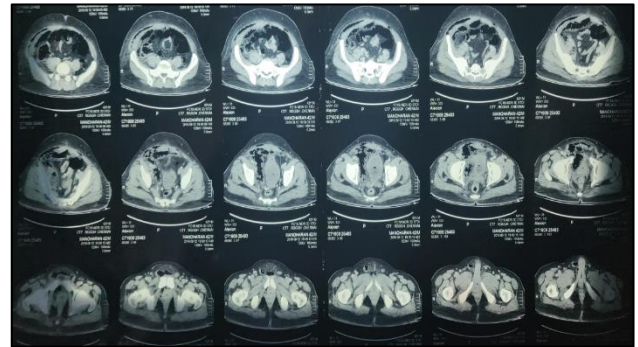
CT abdomen lower cut section showing Fournier gangrene with retroperitoneal involvement.
